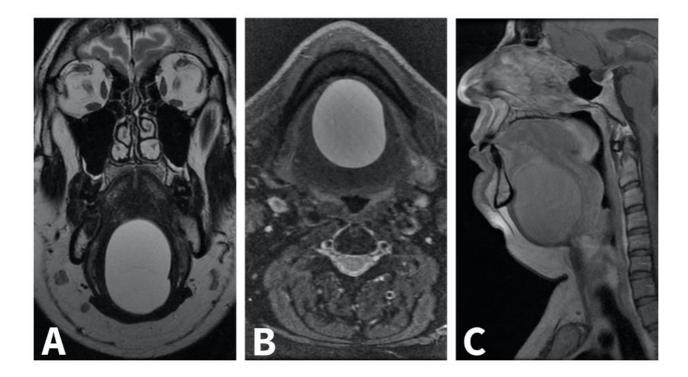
Magnetic resonance imaging (MRI) of a patient with LCRE that demonstrates an approximately 6 cm cystic mass beneath the tongue in the (A) coronal, (B) axial and (C) sagittal planes. The lesion shows high signal on both basic (A) and fat-saturated T2 weighted images (B), no contrast enhancement on T1 sequences (C). These aspects are in keeping with simple fluid collection. (A) COR T2 FSE; (B) AX FRFSE T2 Fat Sat; (C) SAG T1 FSE + contrast.
